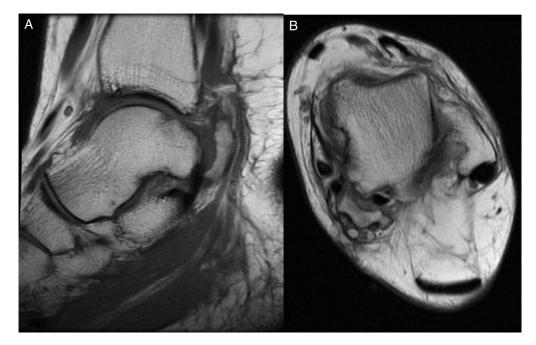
(A and B) Magnetic resonance imaging scan demonstrating an osseous lesion involving the tarsal tunnel and extending from the posteromedial talus.
